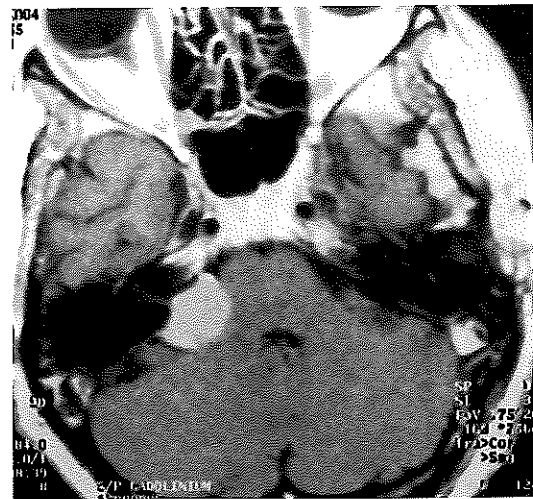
T1-weighted postcontrast axial image of a 24-mm superior petrous meningioma on the right
